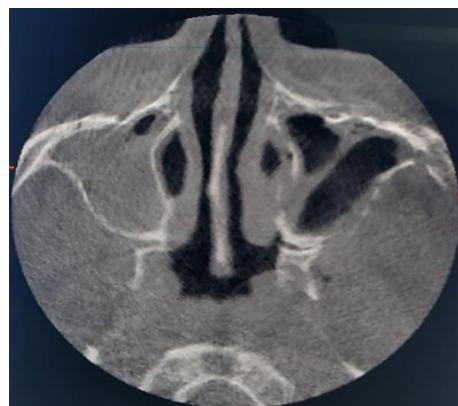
Axial CBCT image showing radiopacification of left and right maxillary sinus, with erosion of anterior, posterior medial wall of maxillary sinus.
